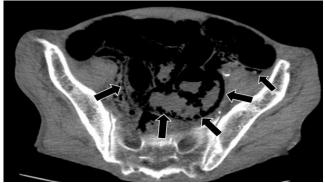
CT section of the non-contrast abdomen through the lower abdomen. Pneumatosis intestinalis is common in the intestinal walls (arrows).
